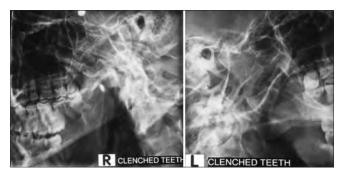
Right and left clenched teeth transcranial view radiograph
